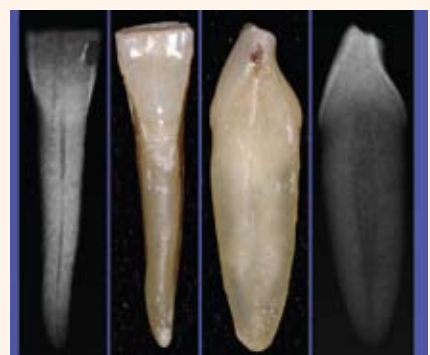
This mandibular incisor appears so frail with a lingual view or radiographic image. It appears husky with a mesial view. It is at least twice as broad buccal lingually.
